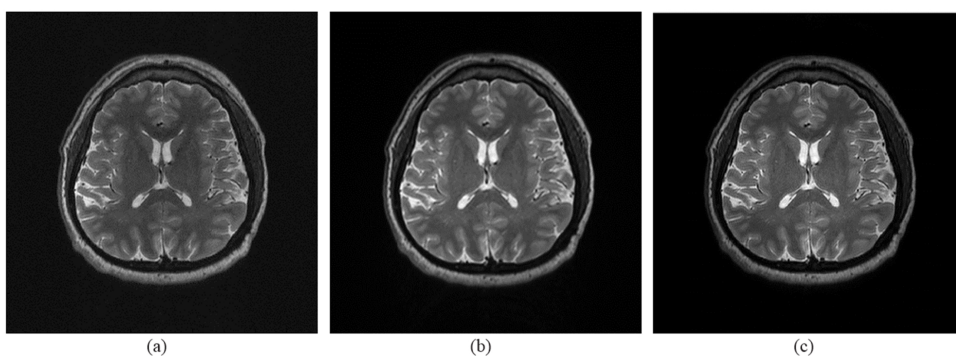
Without any acceleration the proposed method is used for the combination of each channels signal data. (a) SoS of absolute signal data from 32 channel; (b) MRI machines final output image; (c) Provided methods combination of 32 channel. In SoS construction coil inhomogeneity is clear (center of the image is darker than outside in (a)). The machines result (b) and the proposed methods result (c) are similar and homogenous. MRI machine used pre-scan data for inhomogeneity correction but in (c) no additional acquisition data is used. Contrast and details are better in (c) than in (b) in all regions of the brain.
